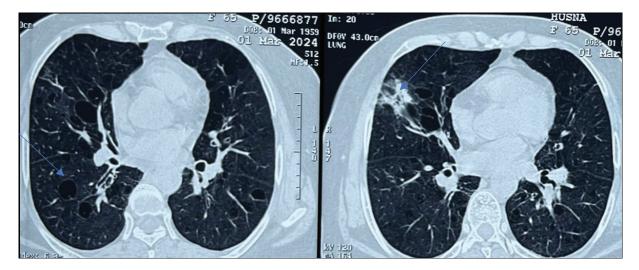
HRCT thorax revealed multiple thin-walled cysts in all the lobes of both lung fields and patchy fibrosis and consolidations at the right middle lobe.
